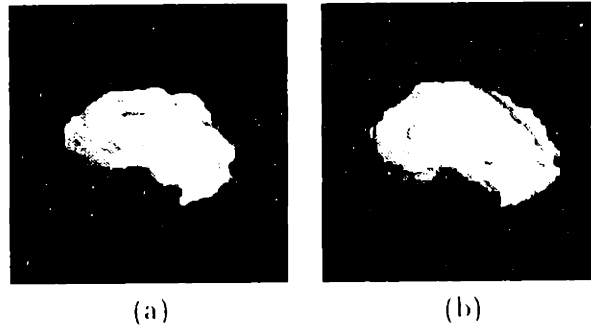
Reconstructions of the left putamen created from MR images. (a) Normal, healthy adult. (b) Patient with schizophrenia.
